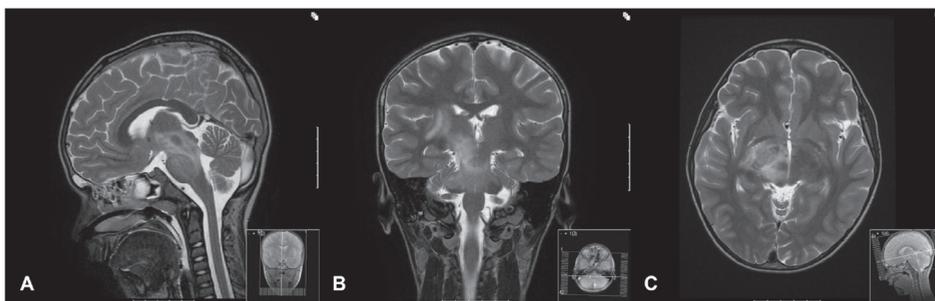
Magnetic resonance imaging findings in the brain of a 9-year-old boy with extensive Bickerstaff brain stem encephalitis during *M. pneumoniae* infection.
